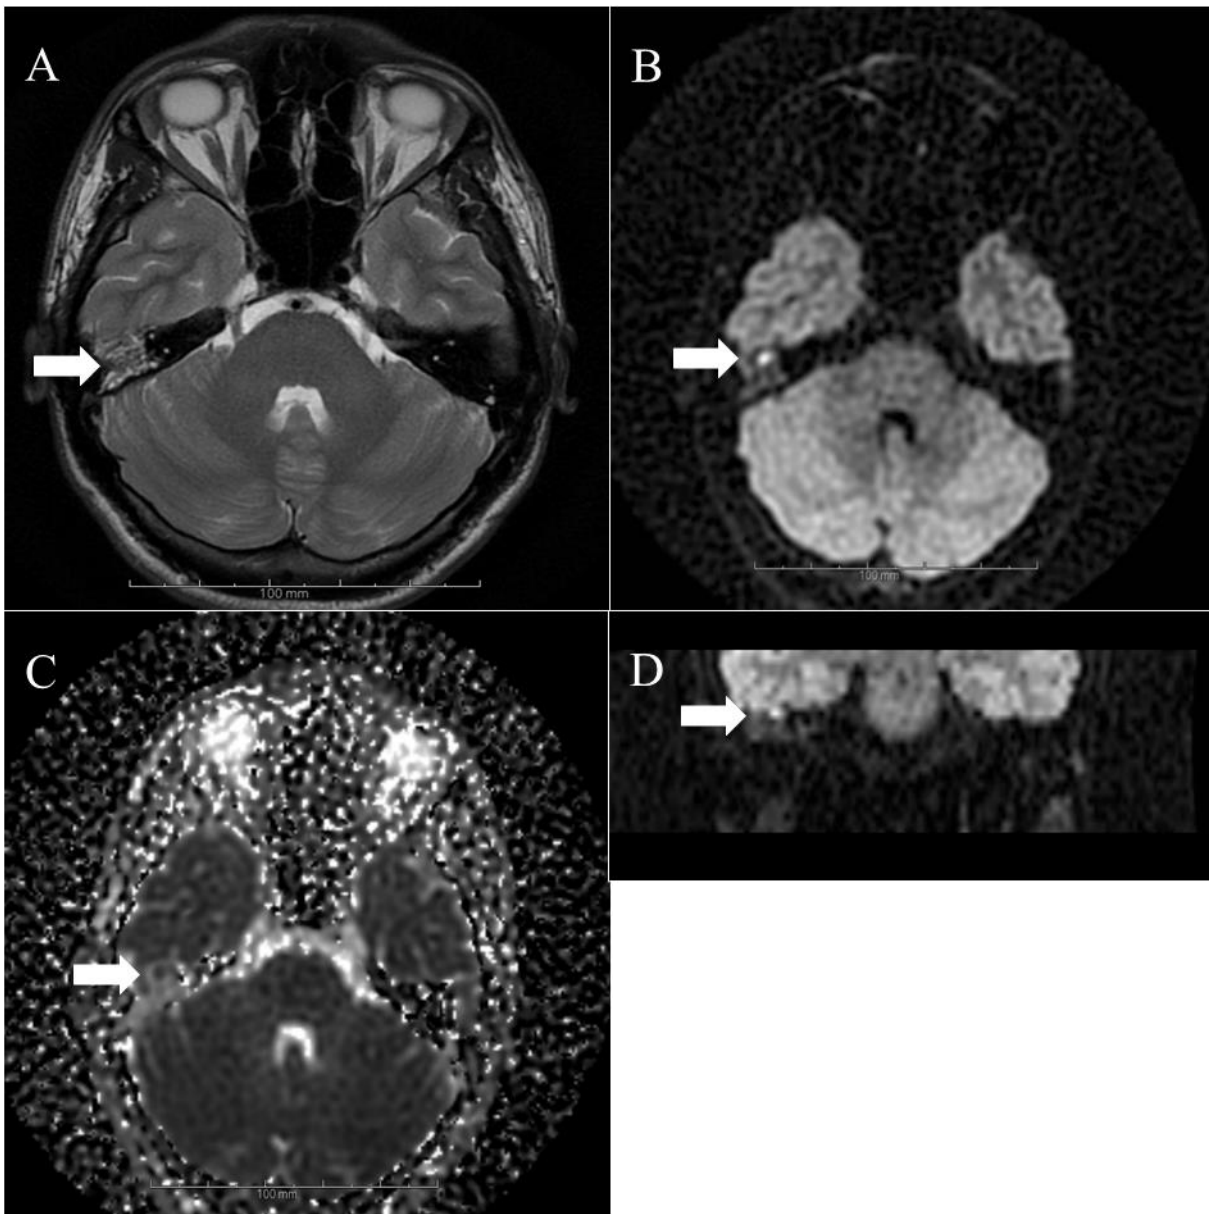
MRI Misidentification: A case of cholesterol granuloma in the middle ear inaccurately resembling cholesteatoma. a) In a 15-year-old, an axial T2WI image reveals a focal, non-uniform hyperintense lesion with an indistinct boundary (white arrow); b) A pronounced hyperintense lesion is noticeable in the epitympanum on axial DW PROPELLER; c) The ADC image displays low-intensity signals (white arrow) d) Coronal reformatted visuals from the axial PROPELLER DWI exhibit hyperintensity on DW PROPELLER. Surgery revealed a small cholesterol granuloma.
